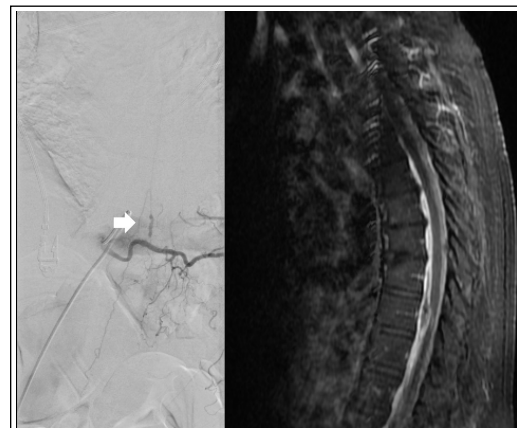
DSA with dissecting aneurysm measuring 2 cm of recurrent radicular medullary branch, artery of Adamkiewicz originating from left T10 and supplying anterior spinal artery. MRI sagittal T1 post-contrast image with heterogeneous, nonenhancing intradural extramedullary mass, spanning from T9 to T11.
